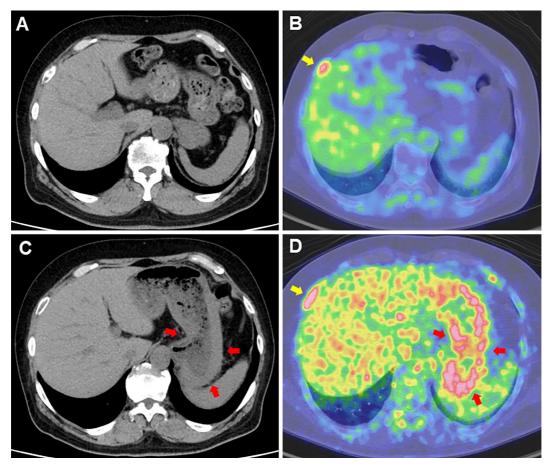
Representative images of computed tomography (CT) and positron emission tomography (PET)-CT. Six months prior to referral to our department, (A) abdominal CT showed no thickening of the gastric wall, and (B) PET-CT showed the accumulation of fluorodeoxyglucose (FGD) in the right rib and bone metastasis (yellow arrow). (C) At the time of referral to our department, abdominal CT showed circumferential thickening of the gastric wall (red arrows), and (D) PET-CT showed progression of bone metastasis (yellow arrow) and an intensive FDG accumulation in the thickening gastric wall and gastric metastasis (red arrows).
